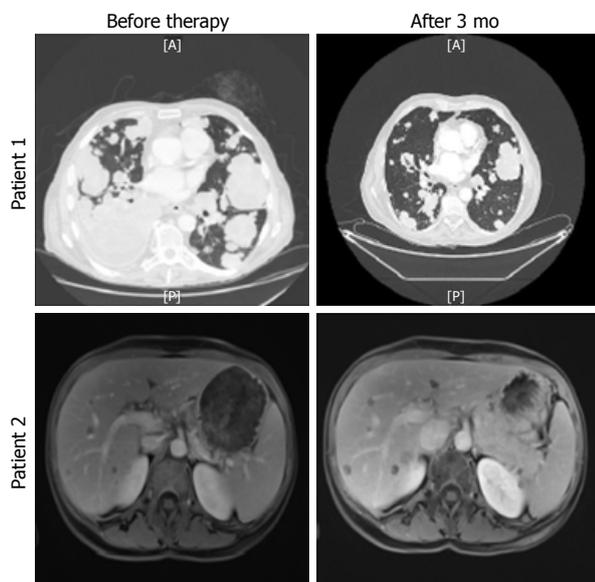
Computed tomography scan of patient 1 before and after 3 mo of olaparib (upper panel), and magnetic resonance imaging of liver metastasis of patient 2 before and after 3 mo of olaparib (lower panel).
